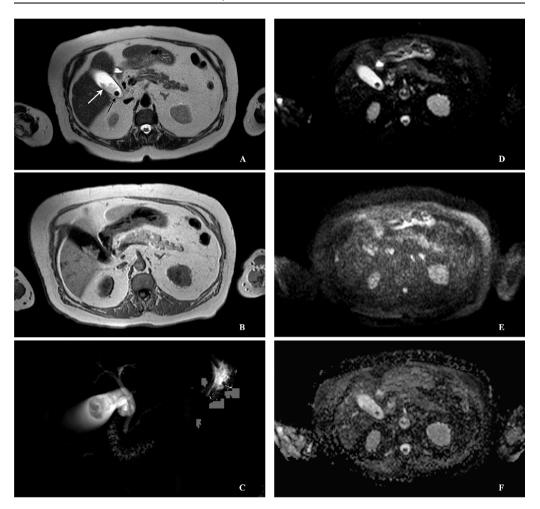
Abdominal MRI of 76 female with a melanoma (white arrow) and gallstone (black arrow) of the gallbladder on T2-weighted (A), T1-weighted (B), pseudo-3D reconstruction (C), diffusion-weighted imagines with 0 (D), and 1000 s mm $^{-2}$ b vale (E), as well as on apparent diffusion coefficient — ADC map (F). Data from authors collection.
